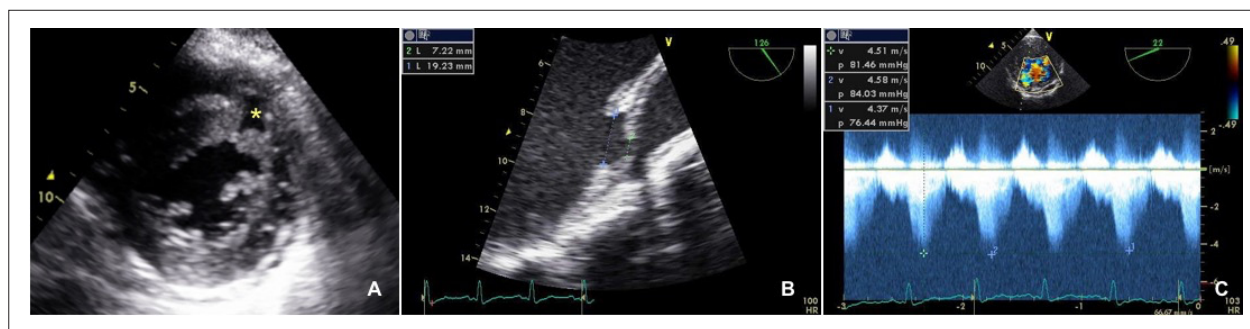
Echocardiographic images of the VSD. Panel A: VSD located in the mid anteroseptal segment. Panel B: VSD measuring 19 mm on the LV side and 7 mm on the RV side. Panel C: continuous wave Doppler estimating peak gradient at 84 mmHg.
